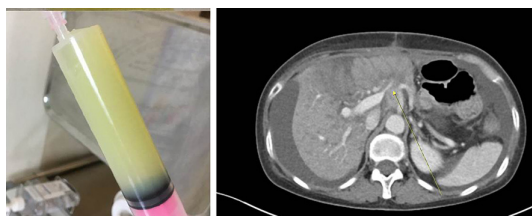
At diagnostic paracentesis, milky ascites drained(Left) and CT scan(Right) shows ascites and narrowing of portal vein with surrounding infiltrative soft tissue.
